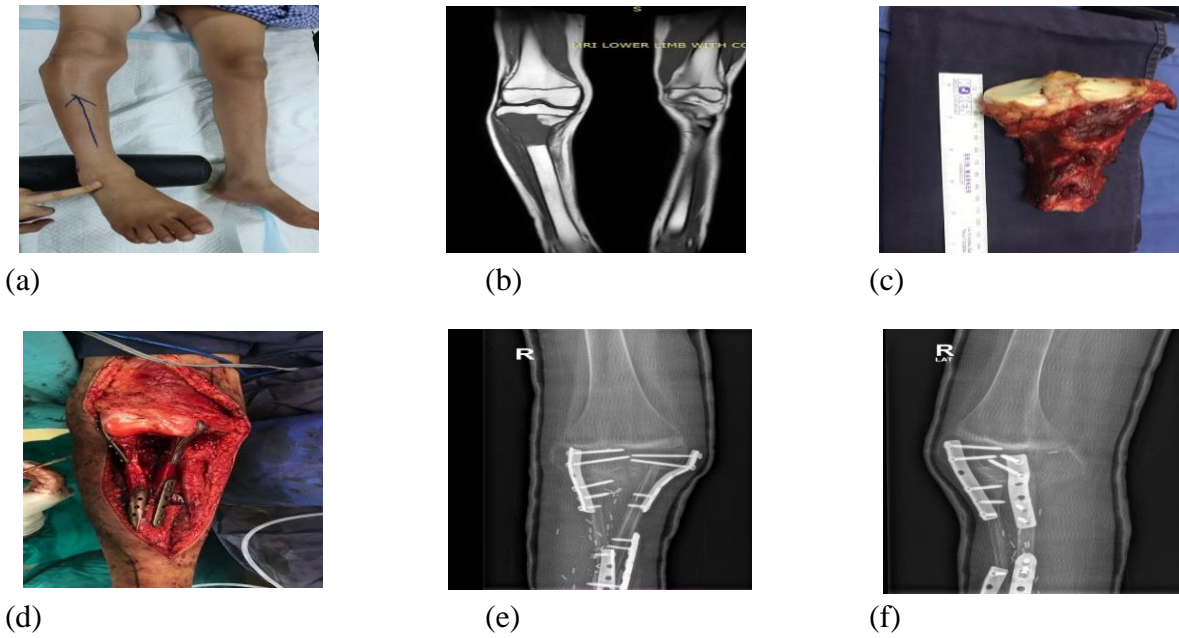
(a) 14 years old male with osteosarcoma of the right proximal tibia (b) MRI image showing tumor of the right proximal tibia (c) Gross picture of 8 cm excised tumor (d) Intraoperative image after fixation of the vascularized fibula as double-barrel with plates and screws (e) & (f) Anterior and Lateral view of X-ray right tibia after 14 months of reconstruction showing the union of bones.
